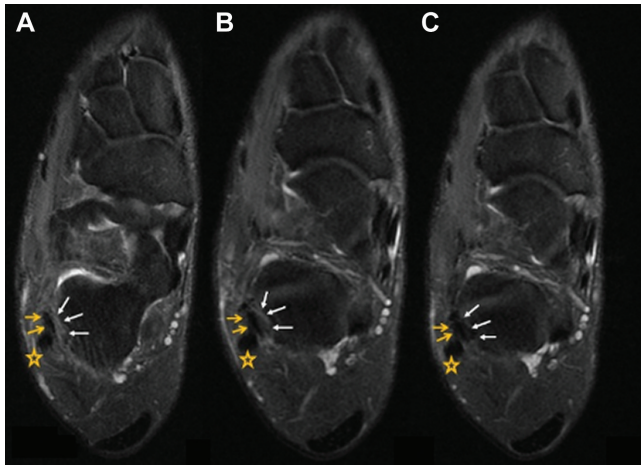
Proton density–fat suppressed weighted sequence with fat-suppressed axial ankle view at (A) 6 months, (B) 12 months, and (C) 24 months after anatomic lateral ankle ligament reconstruction showing the morphological/signal magnetic resonance imaging evolution of the CFL graft—the CFL graft (white arrows), the peroneus brevis tendon (thick arrows), and the peroneus longus tendon (stars). CFL, calcaneofibular ligament.
